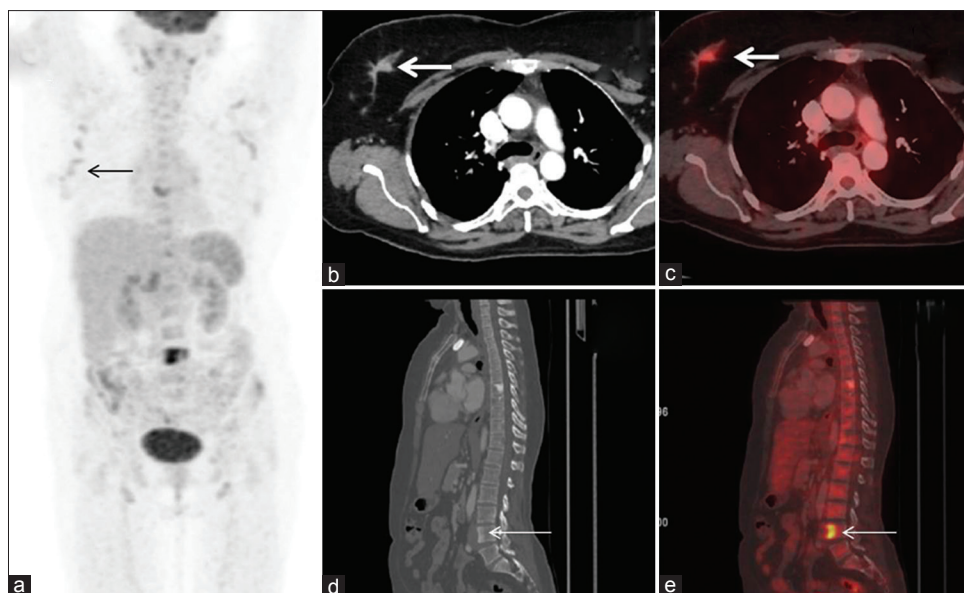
(a) Whole-body, maximum-intensity projection image showing focal low-grade uptake in the right breast (thin black arrow). (b and c): Transaxial contrast computed tomography and fused positron emission tomography/computed tomography images showing enhancing low-grade fluorodeoxyglucose-avid 2.1-cm in the right breast parenchyma (bold white arrows). (d and e) Sagittal computed tomography and fused positron emission tomography/computed tomography images showing metabolically active sclerotic lesions involving D7 and L4 vertebrae suggestive of metastasis (thin white arrows)
